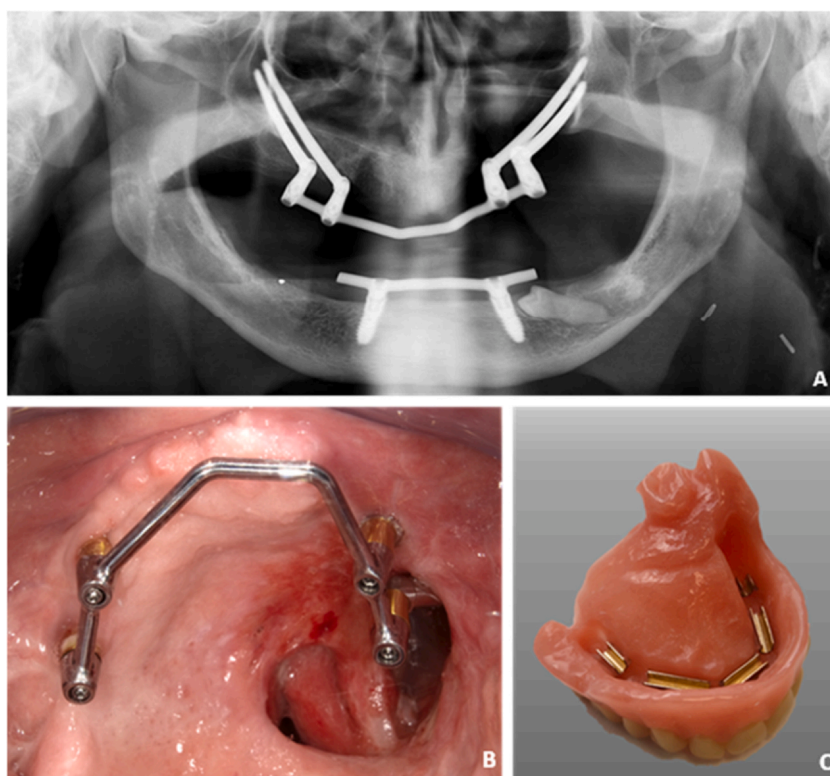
(A) Panoramic radiograph and (B) intraoral views of a patient with a U-shaped cross-arch suprastructure on four zygomatic oncology implants, two positioned in the defect and two on the contralateral side. (C) The matching definitive implant-retained obturator prosthesis.
